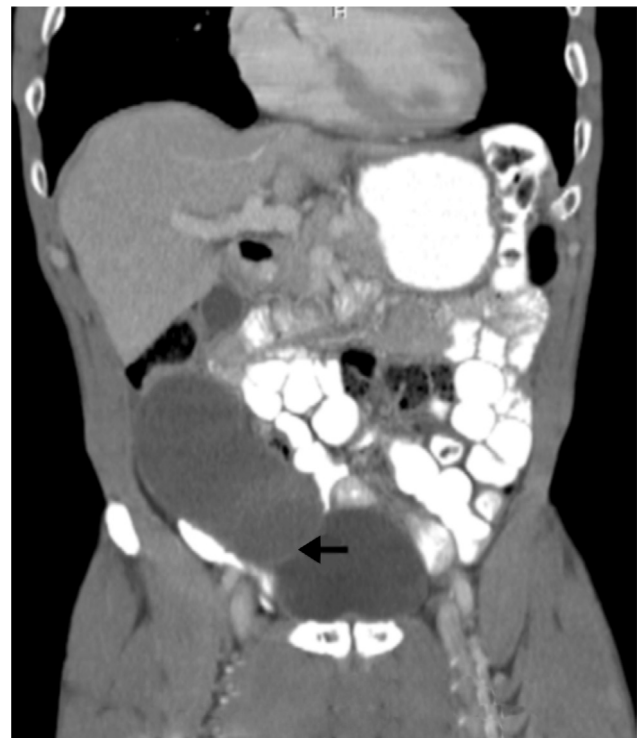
Lesion in topography of cecal appendix, hypodense, in a sagittal CT of abdomen (arrow).
